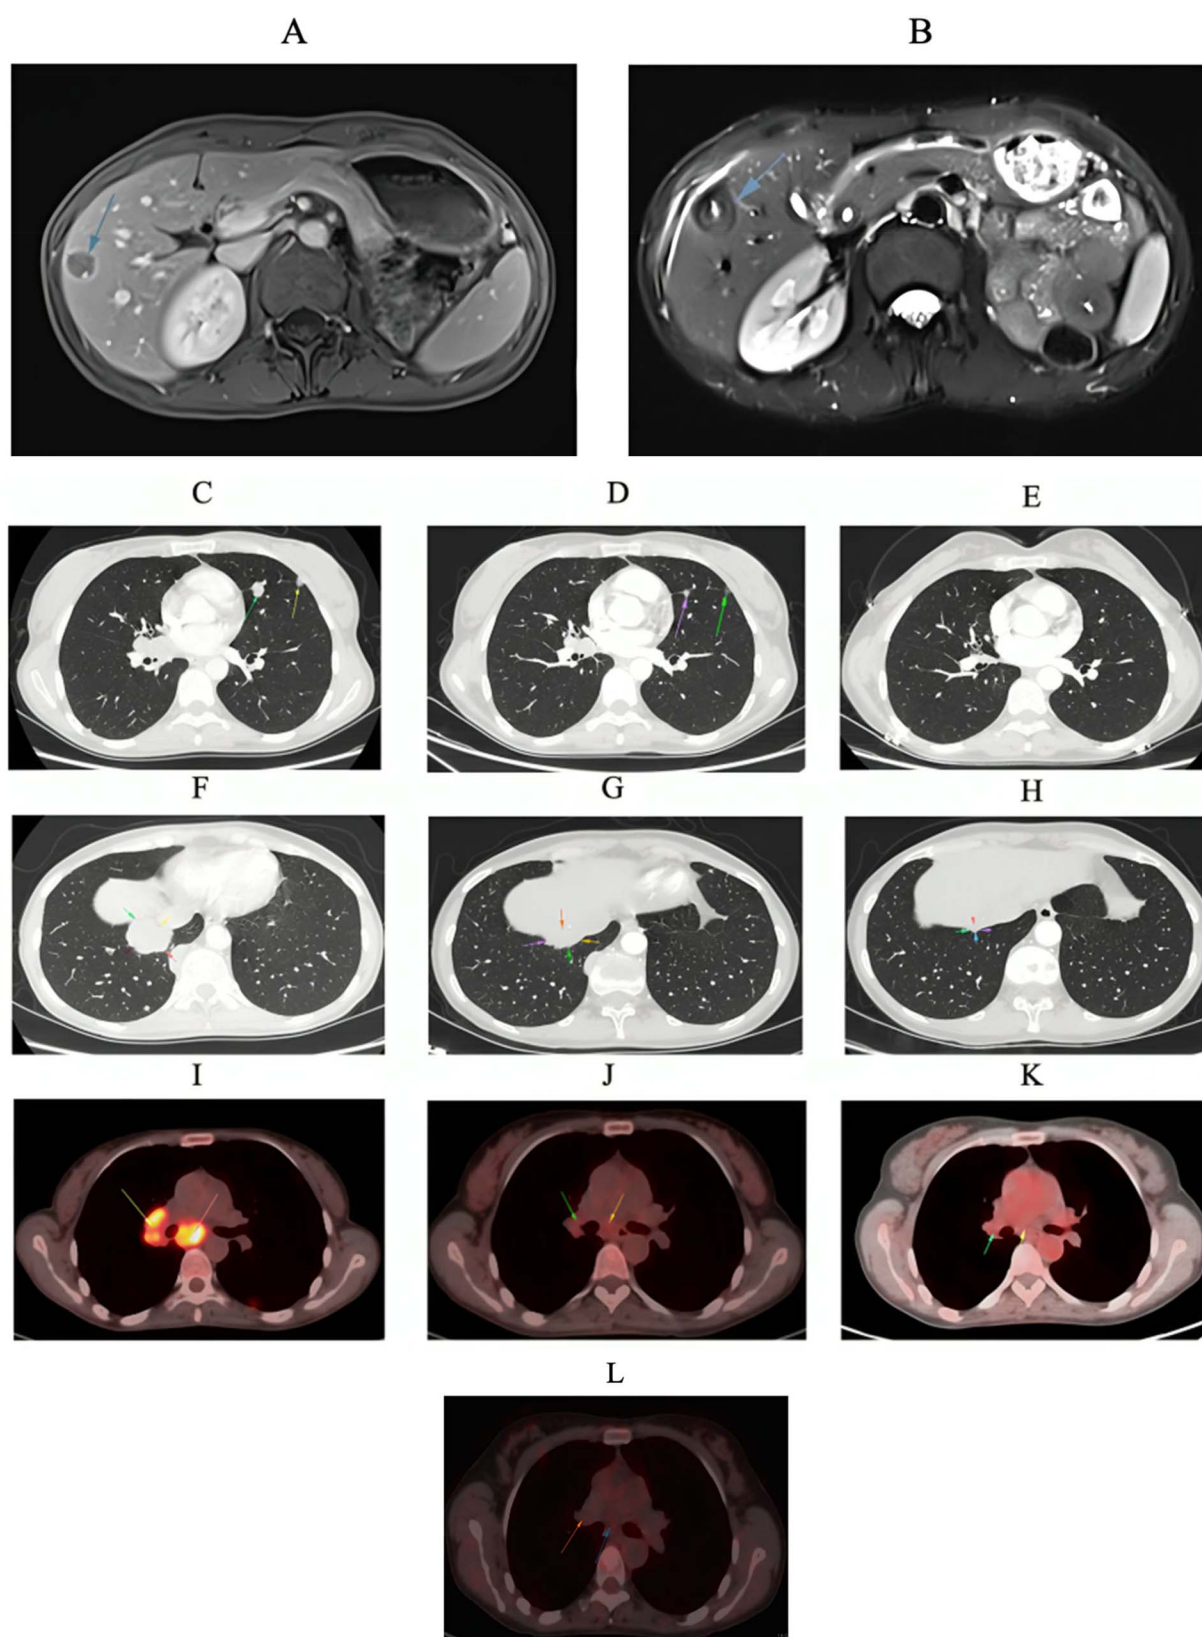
Patient scans showing liver parenchymal lesions (arrows) before (A) and after (B) treatment course. Thorax CT scans before treatment (C and F) and after 3 months (D and G) and 7 months (E and H) of treatment. PET scans before treatment (I) and after 3 months (J), 7 months (K), and 10 months (L) of treatment.
